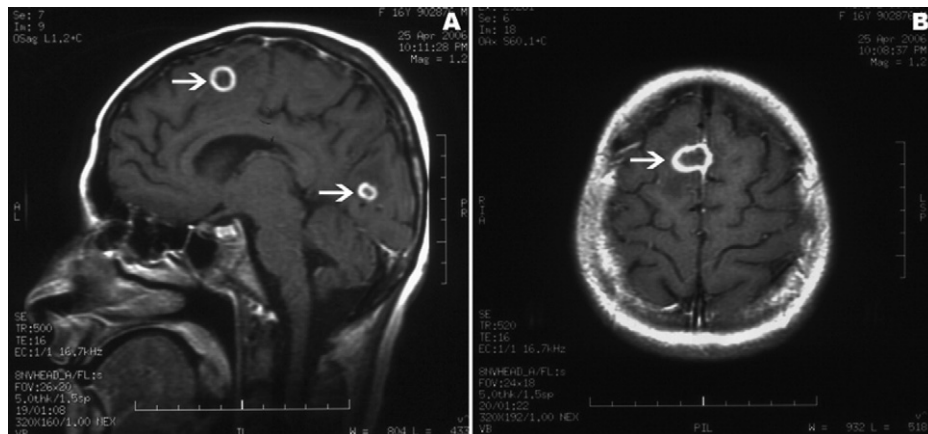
A T1 weighted contrast enhanced sagittal MRI. Right frontal lobe and occipital lobe lesions showed ring enhancement and accompanying edema halo. B T1 weighted contrast enhanced axial MRI of right frontal lobe.
